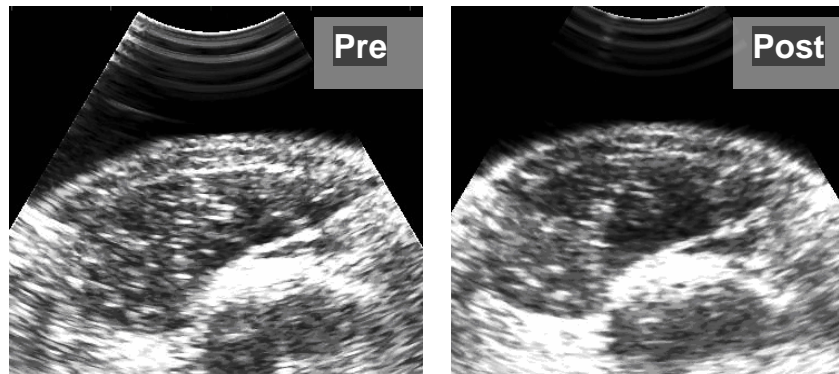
Pre and post-training ultrasonic image of the VMO. Images were selected from a subject of program S.
